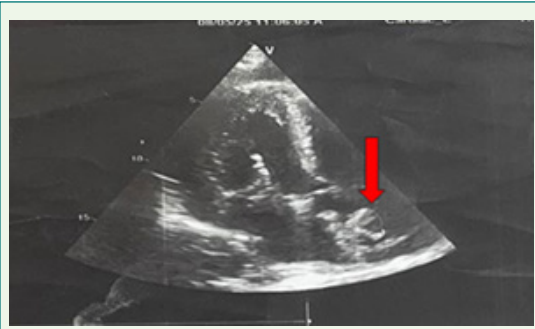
Transthoracic echocardiographic four-chamber view shows a mass (thrombus) attached to the HD catheter that reached the right atrium, with severe mitral regurgitation.
